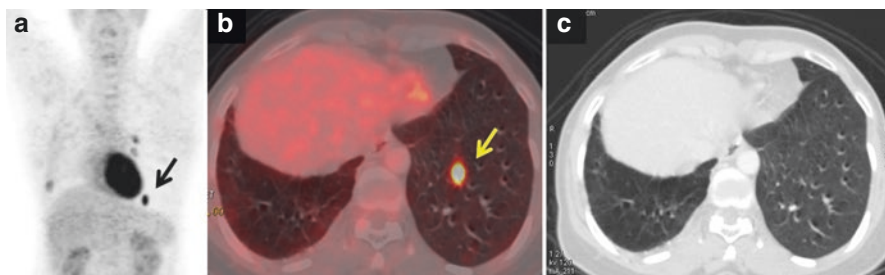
(a) MIP of FDG PET/CT scan shows an intensely FDG-avid focus in the base of the left lung (arrow). Axial fused PET/CT image (b) shows the hypermetabolic focus in the lower lobe of the left lung (arrow). No corresponding lesion is noted in the left lung in the axial CT image (c). This is seen due to faulty injection leading to formation of a microembolus mixed with the radiotracer which then gets trapped in the pulmonary microcirculation giving this a typical appearance
